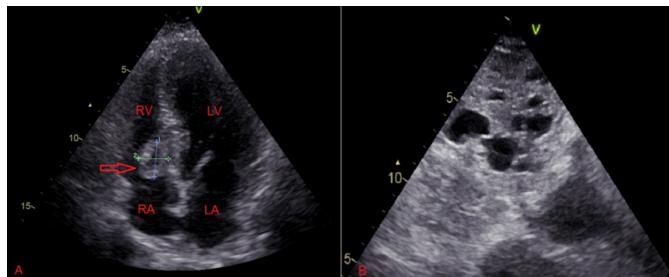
(A) Two-dimensional echocardiography in an apical-four chamber and (B) subcostal echocardiography views showing the blood cyst (arrow); attached to the interventricular septum in A and multiple hepatic cysts in B.
